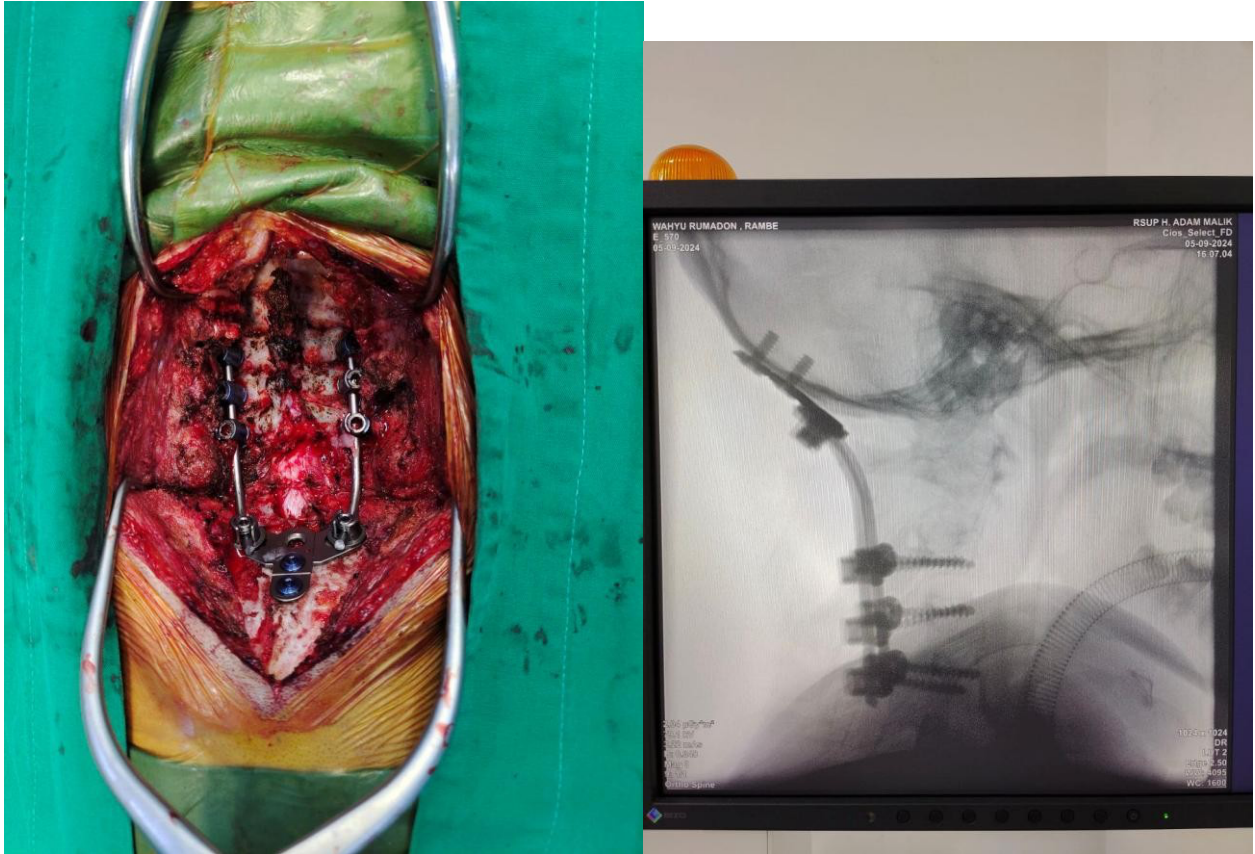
Lateral plain radiograph of the cervical spine post occipitocervical fusion, showing proper placement of occipital and cervical instrumentation from the occiput to C3. The alignment is restored, and the hardware maintains stability across the craniocervical junction.
